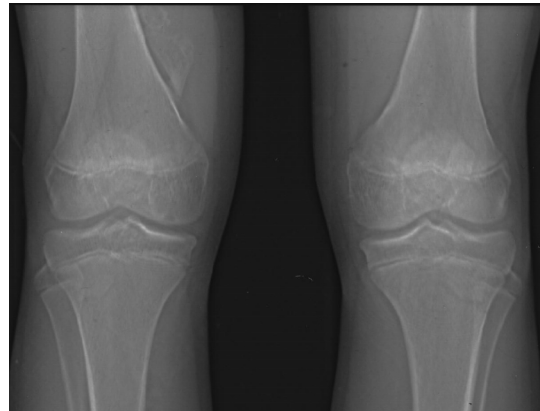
Anteroposterior radiograph obtained at 13 years of age immediately after the injury
